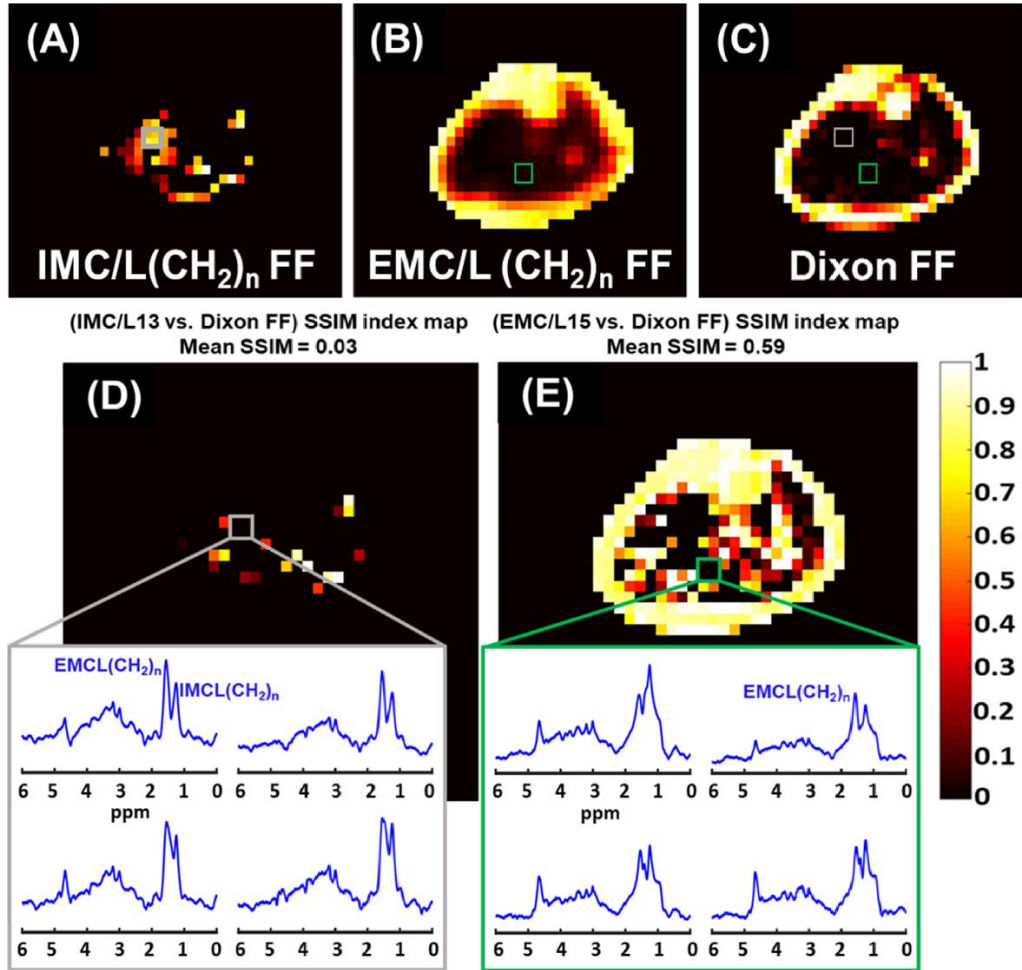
Fat fraction (FF) distribution maps of MRSI IMC/L(CH<sub>2</sub>)<sub>n</sub> (A), EMC/L(CH<sub>2</sub>)<sub>n</sub> (B), and the Dixon-MRI undifferentiated-fat-fraction image (C). The Dixon MRI image was down-sampled to MRSI resolution for a better comparison. The corresponding SSIM index maps show the structural similarity (SSIM) between the Dixon signal FF image and the MRSI IMC/L(CH<sub>2</sub>)<sub>n</sub> FF map (D), and the EMC/L(CH<sub>2</sub>)<sub>n</sub> FF map (E). The mean SSIM value is listed above each SSIM map. The dark areas of SSIM = 0 on the maps (box) represent total mismatching between MRSI and the used Dixon method results. Within these areas, only MRSI could identify lipid peaks
